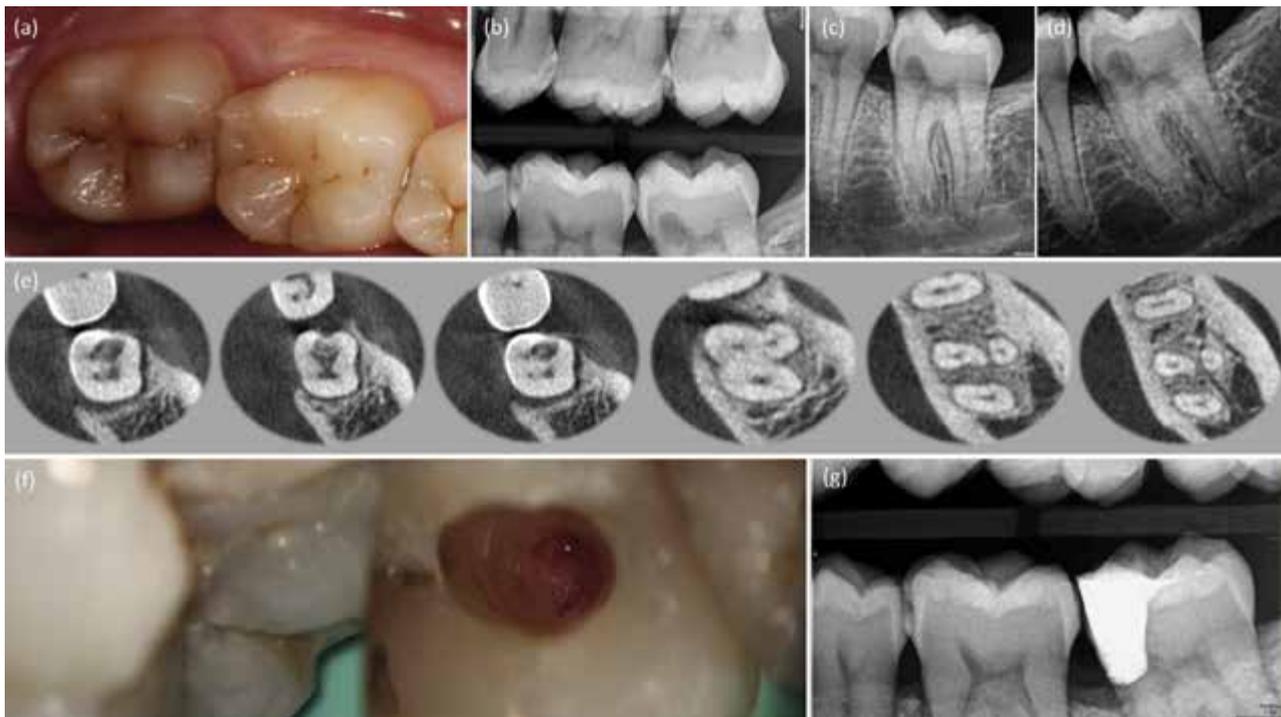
(a, b) A 45-year-old woman was referred by her general dental practitioner for endodontic management of a possible external cervical resorption lesion on the tooth 37. On presentation, the patient was asymptomatic. (c, d) Periapical radiographs of tooth 37 using a paralleling technique revealed a well-circumscribed and symmetric radiolucency in the cervical aspect of the tooth. (e) Axial cone beam computed tomography (CBCT) (ProMax 3Ds; Planmeca Oy, Helsinki, Finland) slices through tooth 37 showing a radiolucency with defined margins. The resorptive lesion had not perforated into the root canal. Furthermore, axial slices allowed the relationship between a supernumerary root (distolingual) and the other roots to be assessed. (f) The external cervical lesion was treated by an internal approach. (g) A post-operative periapical radiograph.
